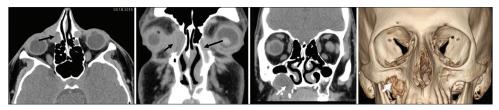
Axial computed tomography scan showing right cystic lesion, fluid-filled structure (black arrows). Bilateral dilatated nasolacrimal duct ending in bone obstruction. Lacrimal gland marked hypoplastic on the right side and hypoplastic on the left side. In the temporal bone, the middle ear ossicles were normal on both sides. Coronal and 3-D coronal surface shaded display fluid containing destructive expansible lesion originating from the alveolar process of the right maxilla (white arrow). Expansive lesion seen involving from the right maxilla is no longer seen after lacrimal cyst removal
